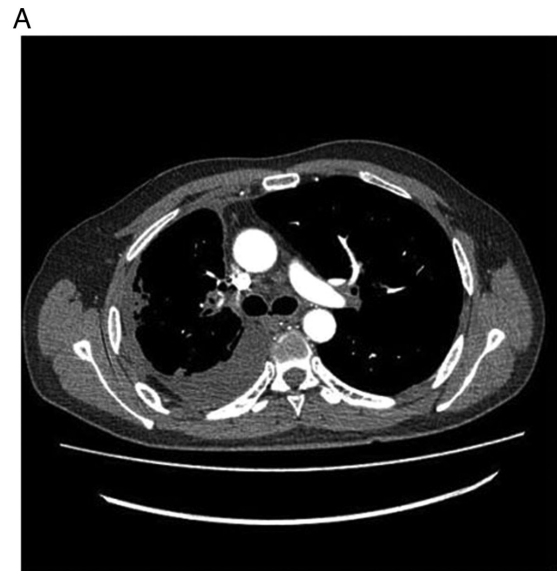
(A) Mediastinal and (B) pulmonary windows of chest CT after 18 days of treatment with lorlatinib. The mass of the lung is smaller than before.
